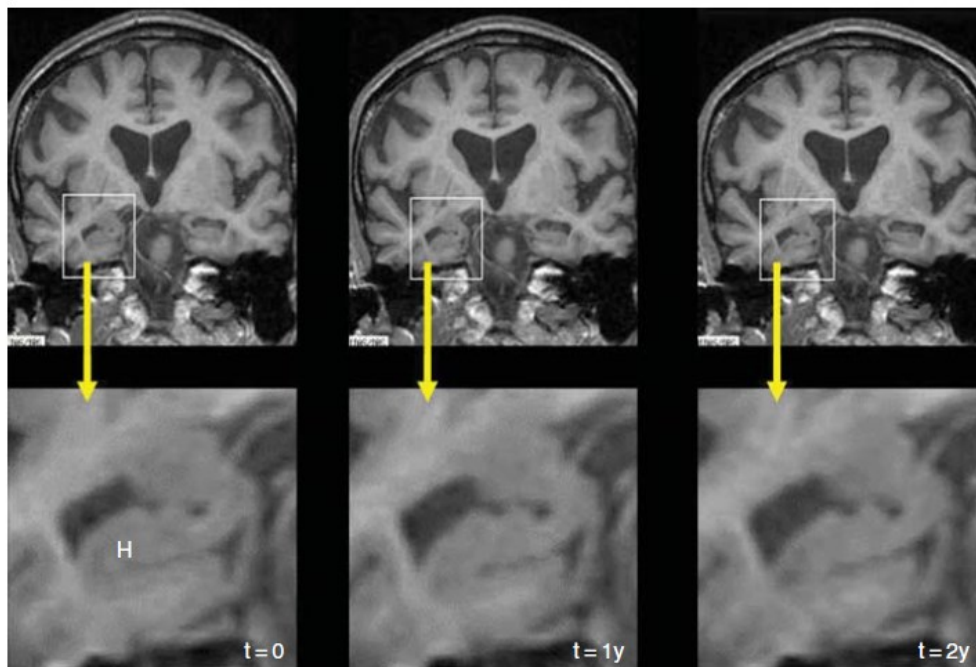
Series of structural MRI scans, each taken approximately 1 year apart, showing progressive hippocampal atrophy as individual progressed to AD [3].
